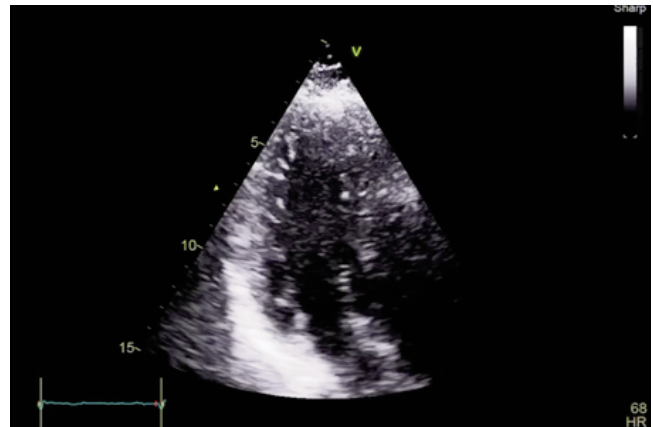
Transthoracic Echocardiography after 5 weeks showing resolution of vegetation.
